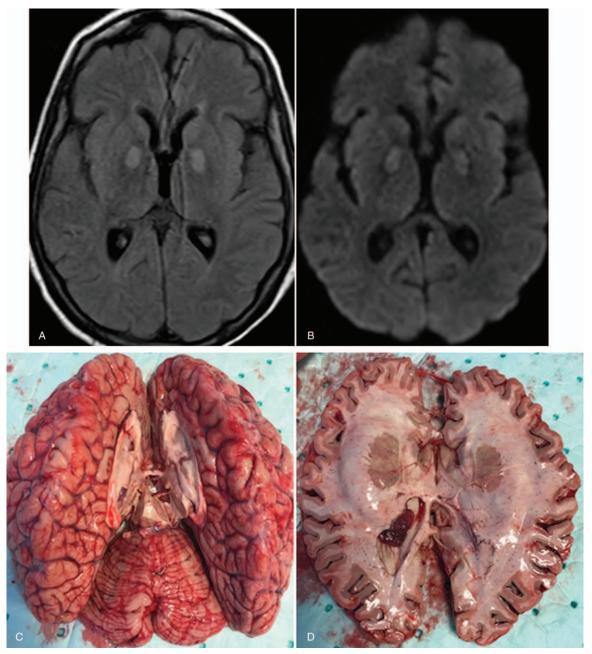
A, Axial FLAIR image, (B) axial DWI image. Symmetric hyperintense foci on FLAIR sequence with restricted diffusion in the globus pallidus. C and D, Macroscopic images of the brain, showing the absence of inflammatory process.
